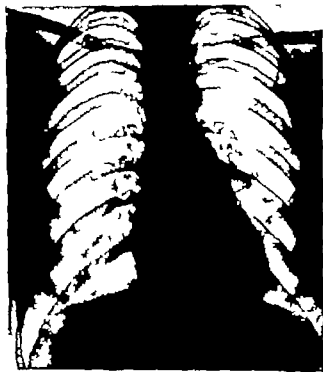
18.—Mass radiography of symptomless tumour near left hilum
